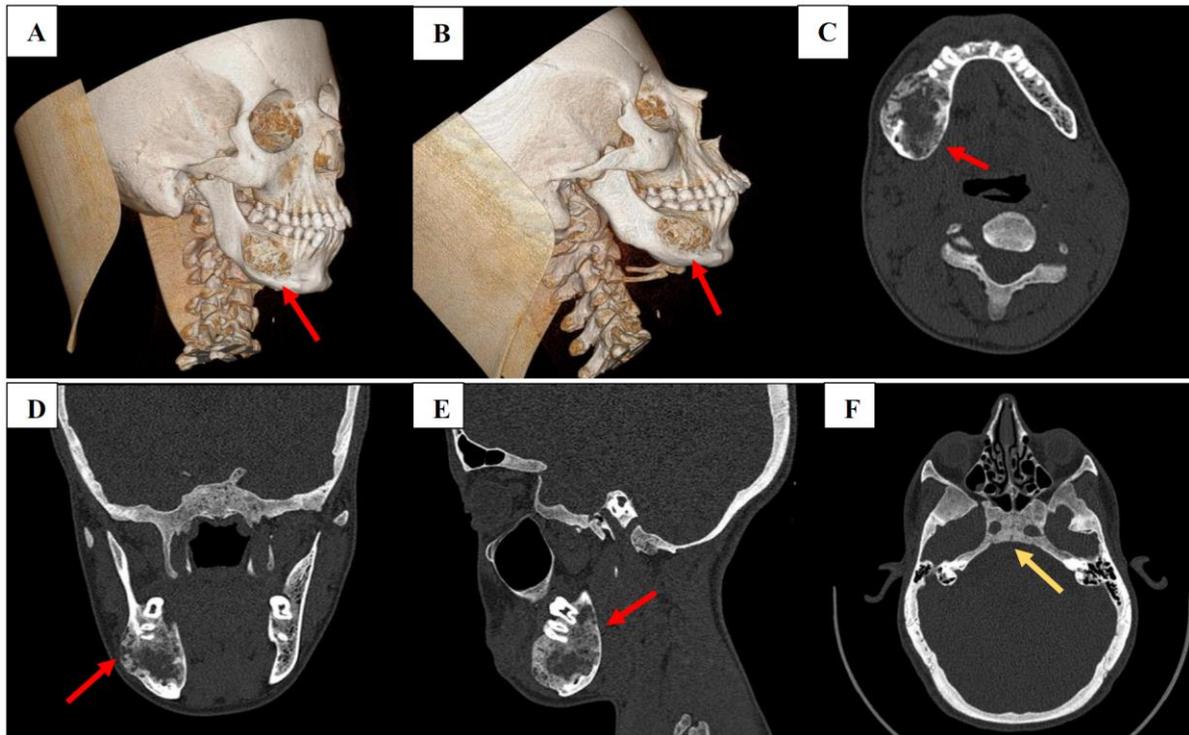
Three-dimensional reconstruction (A, B), axial (C), coronal (D) and sagittal (E) CT scan images in bone windows showing that the lesion is encompassing tooth roots of the 44 to 48 ones, associated with cortical thinning and blowing (red arrows). Also noting the diffuse ground-glass appearance (yellow arrow) mostly marked in the sphenoid bone (E)
